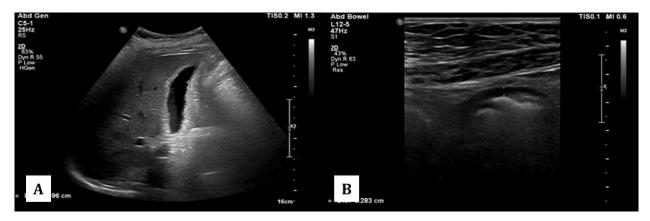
(A) Ultrasound of gallbladder, (B) Ultrasound of Whole Abdomen (bowel loop).
